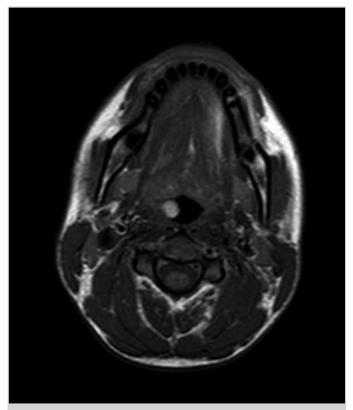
Axial T1 weighted magnetic resonance imaging of the mass
